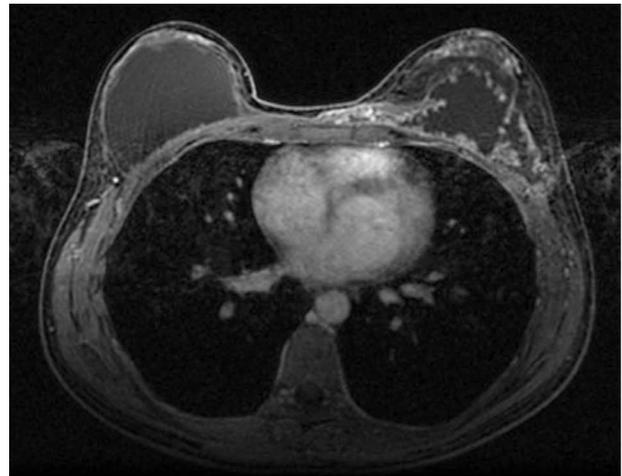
Typical MRI images after PAAG breast augmentation.
